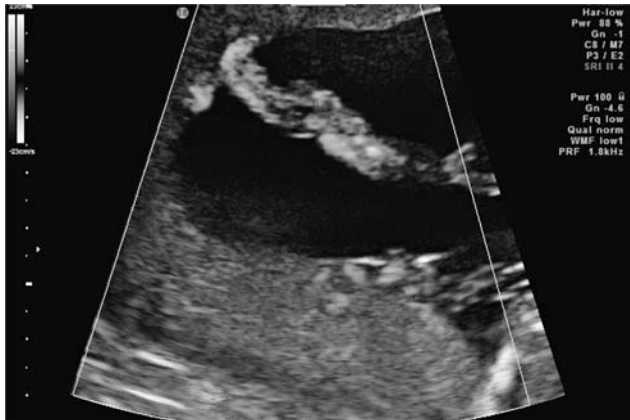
Ultrasound image shows two umbilical cords inserted without amniotic membrane in-between in monoamniotic twin pregnancy.
